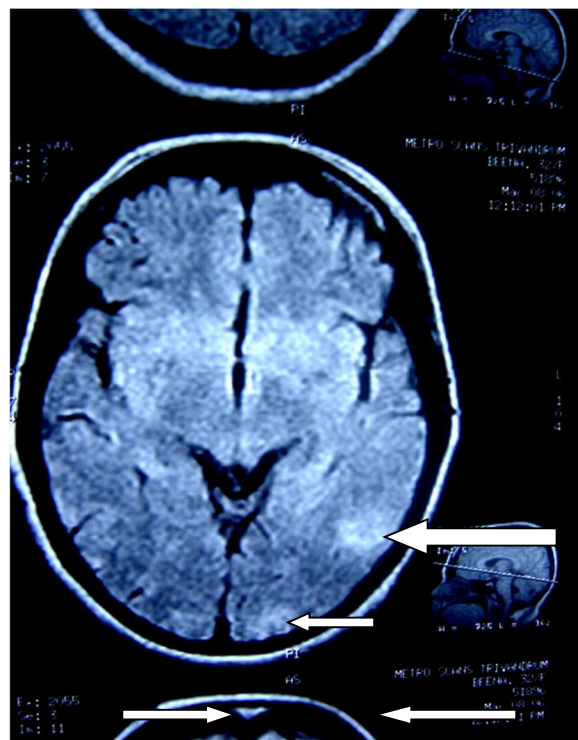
MRI: flair axial section: Two hyper intense lesion in the left occipital lobe
